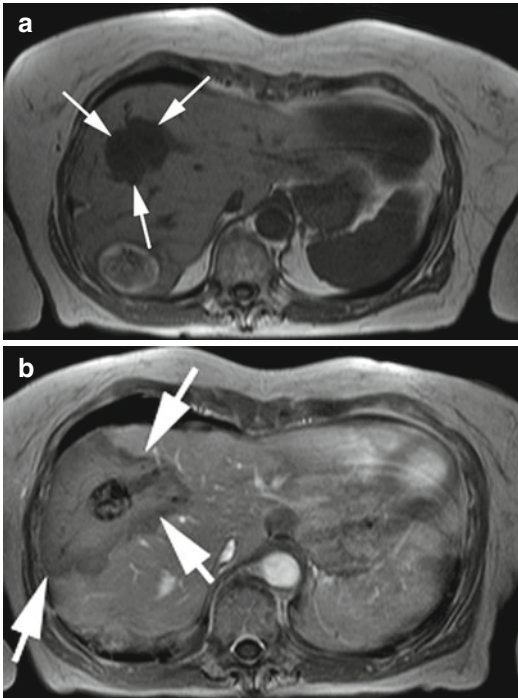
(a) The T1-weighted plain image shows a liver metastasis (*arrows*) with a diameter of 4.9 cm. (b) The contrast-enhanced MR image 24 h after LITT is showing the obtained coagulation area (*arrows*), significantly exceeding the initial tumor volume
